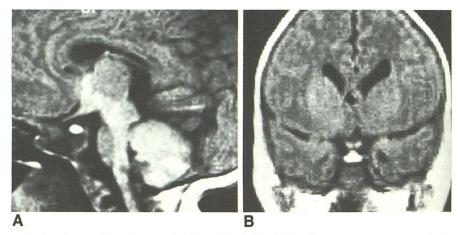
Sagittal (A) and coronal (B) T1-weighted (SE 600/17) MR images show bright pituitary gland in both planes. Age: 12 days; diagnosis: Chiari II malformation.
